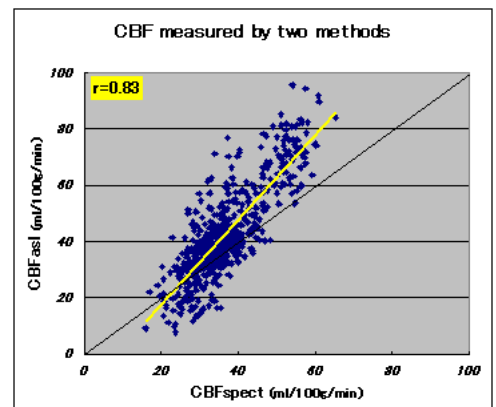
Comparison of rCBF by ASL and SPECT. CBF obtained from ASL have good agreement (r=0.83) with that from SPECT. In higher CBF region, ASL tends to overestimate CBF value compared with SPECT.
